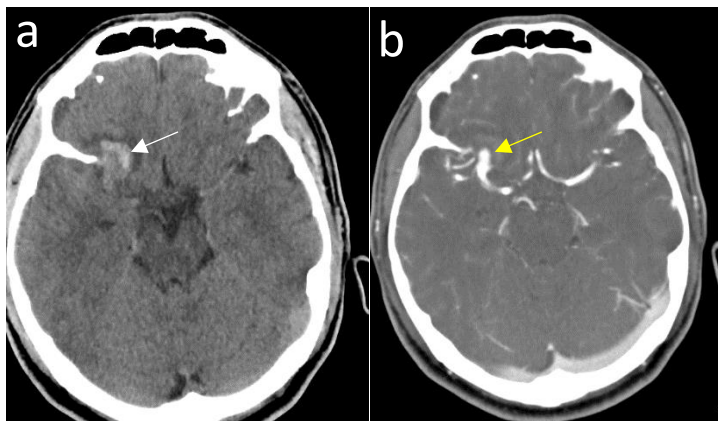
CT scan showing SAH and a small temporal hematoma (white arrow) (a); CTA showing the aneurysm of MCA (yellow arrow) (b)
